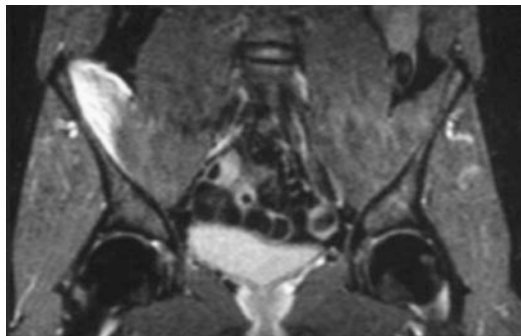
MRI: right iliac muscle contusion in a professional soccer player
